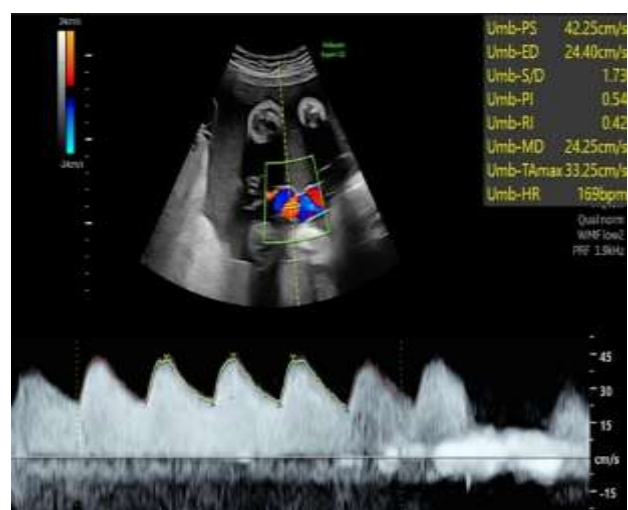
Umbilical artery Doppler for twin 2.
